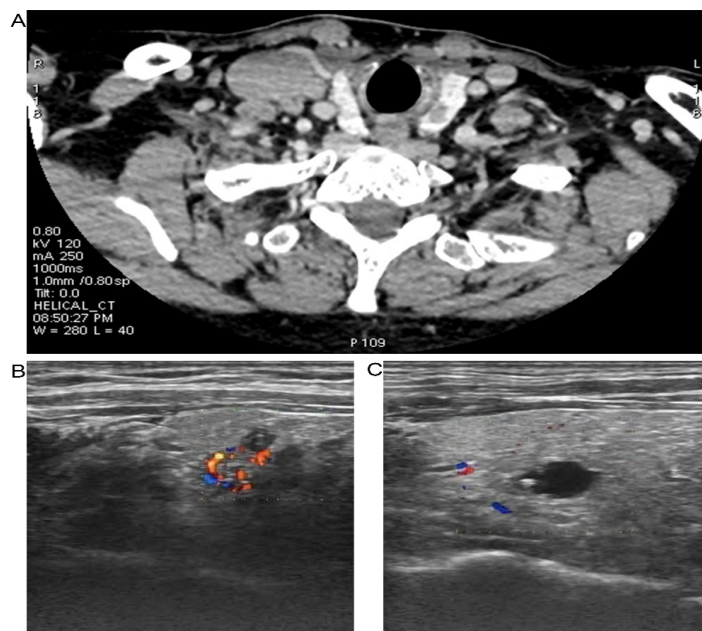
Imaging examinations: Computed tomography revealed (A) The low density shadows of bilateral thyroid and multiple enlarged lymph nodes. Neck Ultrasound revealed (B) Right thyroid solid nodule (TI-RADS 4A classification) and neck hypoechoic nodules, (C) Size of the largest one was 37×21mm.
